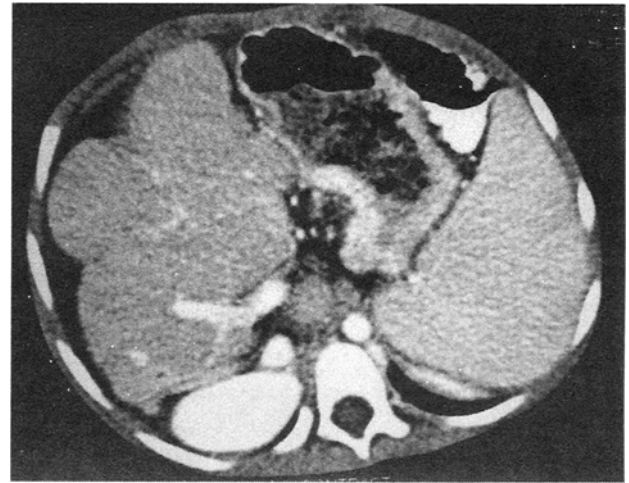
Contrast enhanced axial CT scan shows lobulated outline of liver, atrophy of right lobe, hypertrophy of left lobe, prominent portal vein, splenomegaly. These features are suggestive of cirrhosis of liver with portal hypertension.
